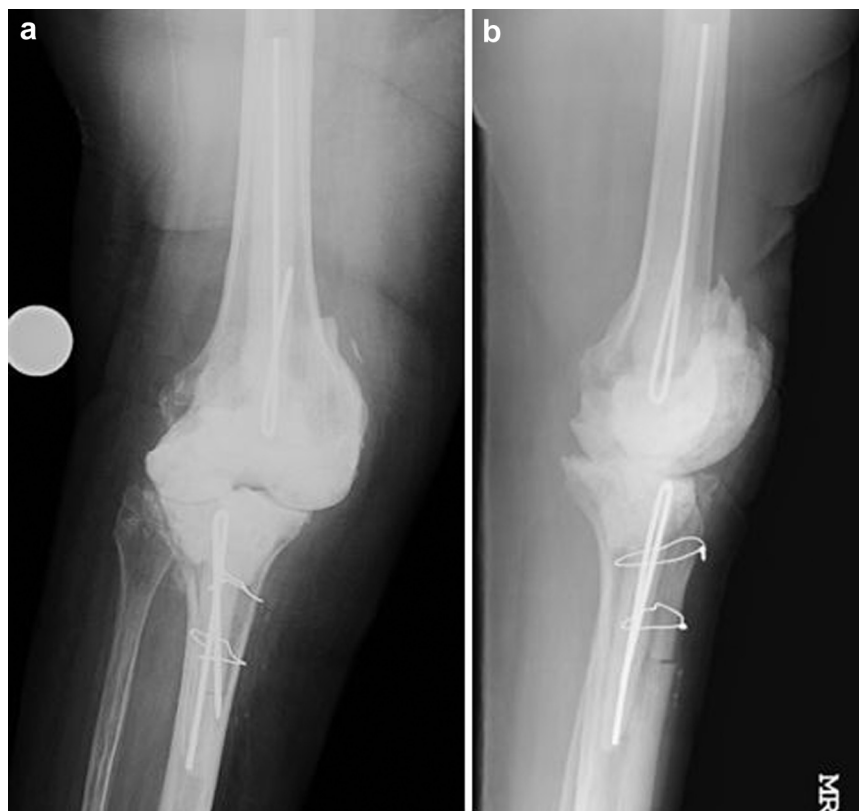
Postarticulating spacer radiographs. Anteroposterior (a) and lateral (b) radiographs after stage 1 articulating antibiotic spacer.
